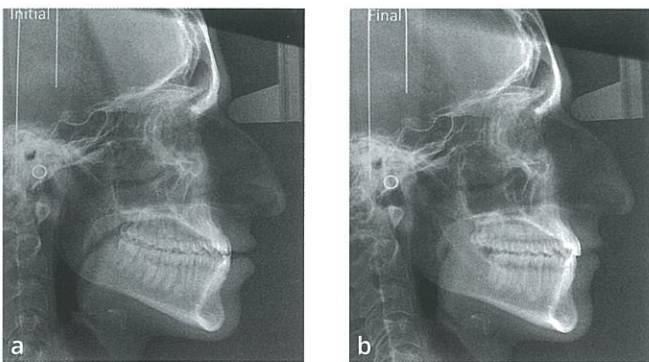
Case 2. Comparison of initial (a) and final (b) lateral radiographs.
